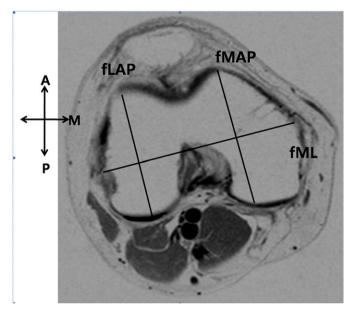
Axial MRI image of the distal femur showing the mediolateral length of distal femur (fML), the medial anteroposterior length (fMAP), the lateral anteroposterior length (fLAP).
